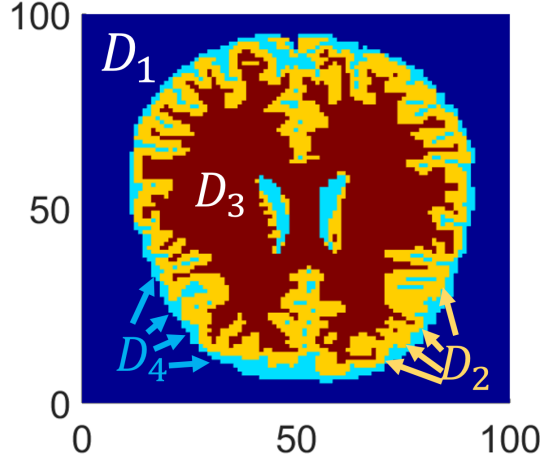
Mask provided by MRI that is used for the two-level parametrisation. The dark blue region D_1 of background matter surrounds the brain tissues cerebrospinal fluid (CSF) matter D_4 in light blue, grey matter D_2 in yellow and white matter D_3 in dark brown.
